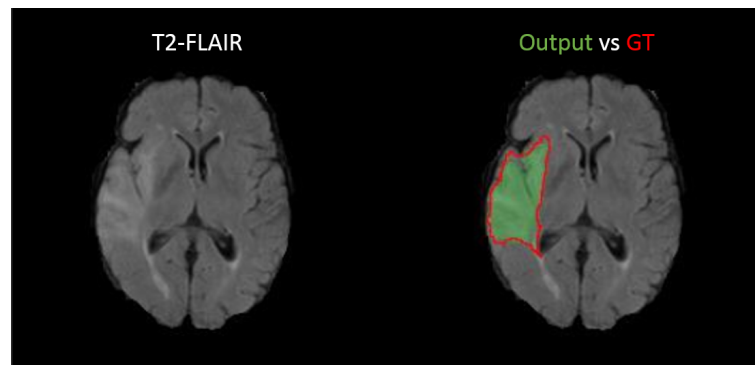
Left: axial slice of a brain MR image presenting a malignant tumor. Right: GT truth (red contour) vs segmentation produced by our semi-supervised method.
